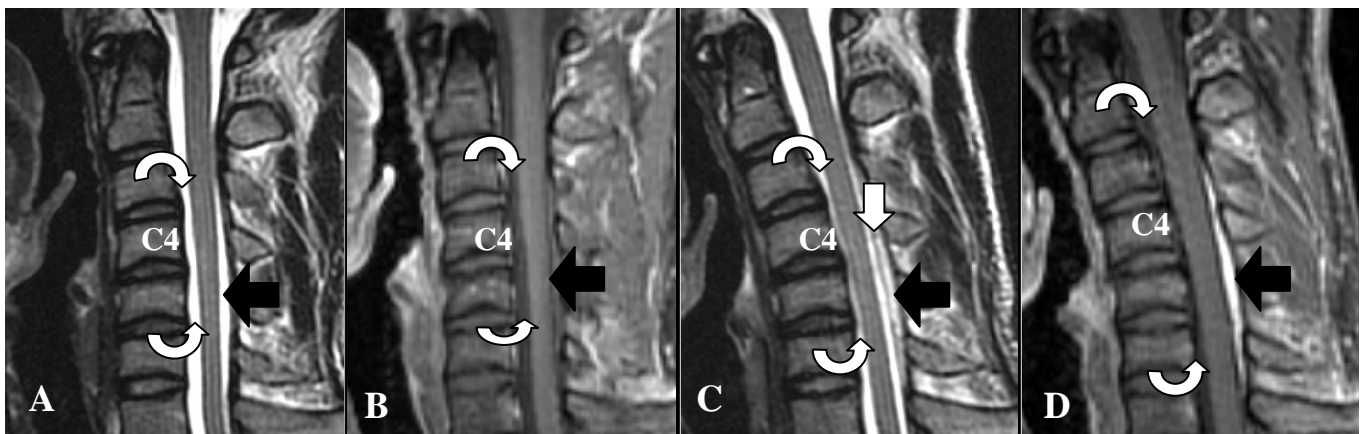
Cervical MR images. A, T2-weighted (3300/114) and B, contrast-enhanced (600/18) nonflexion sagittal MR images show wide subarachnoid space ventral to the spinal cord at C4 and C5 vertebral levels (curved arrows in A and B). The posterior dura is closely contact with spinal canal (black arrows in A and B). C, T2-weighted (5550/99) and D, contrast-enhanced (617/20) flexion MR images show forward displacement of tightened dural sac (white arrow in C) and the large posterior epidural plexus with enhancement (black arrows in C and D) from C3 to C6 levels. The spinal cord is compressed anteriorly by the C4 and C5 vertebral levels and causes narrowing of anterior subarachnoid space (curved arrows in C and D).
